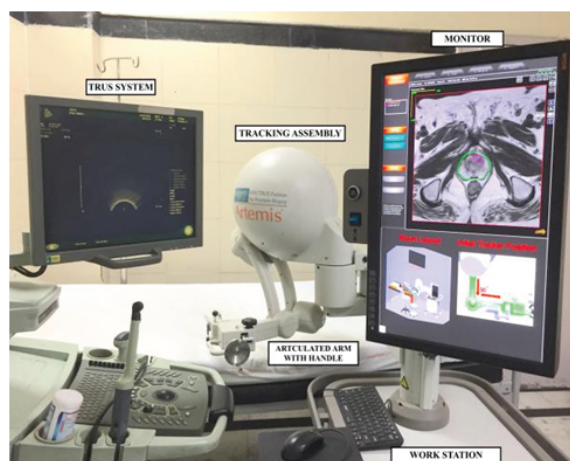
Photograph showing MRI/TRUS Eigen-Artemis fusion biopsy platform with transrectal ultrasound system (left side) and fusion device with monitor and the tracking assembly (right side)
